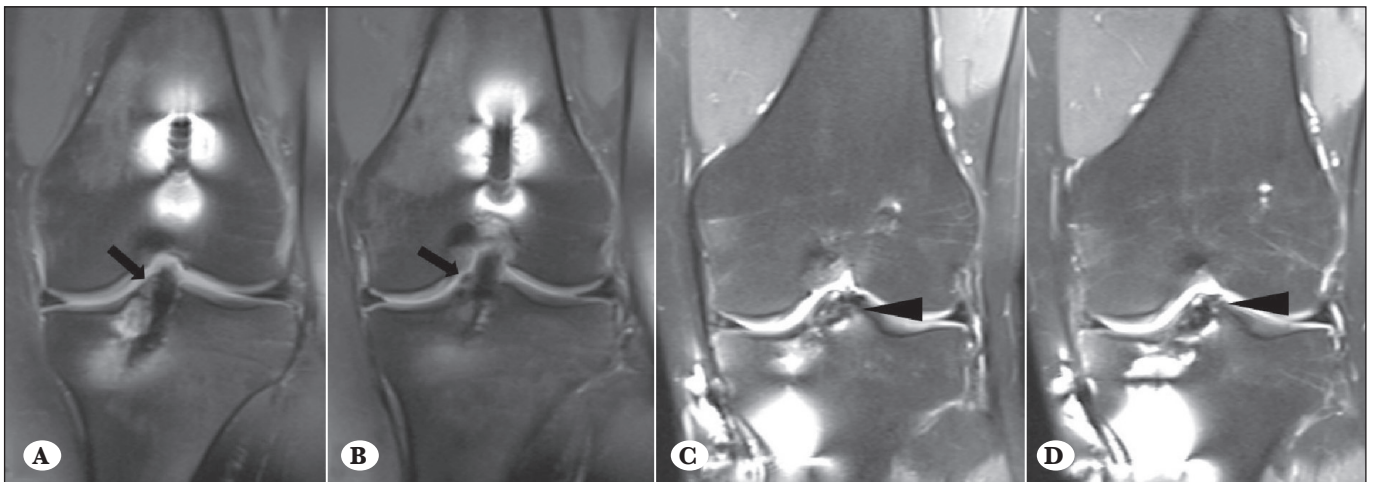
Coronal PD-weighted fat suppressed MR images showing (A, B) that the graft was mildly impinged by the margins of the tibial tunnel (arrow). (C, D); the graft was mildly impinged by an osteophyte (arrow head) from the tibial plateau and margins of the tibial tunnel.
